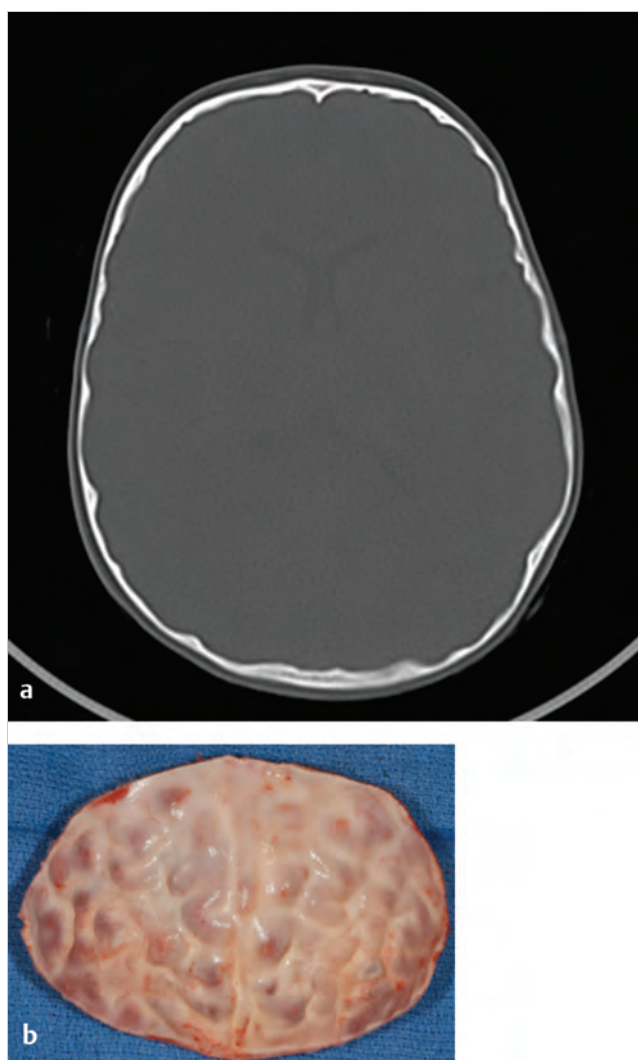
Endocortical erosions. (a) CT findings. (b) Intraoperative view of the frontal bone with endocortical scalloping.
